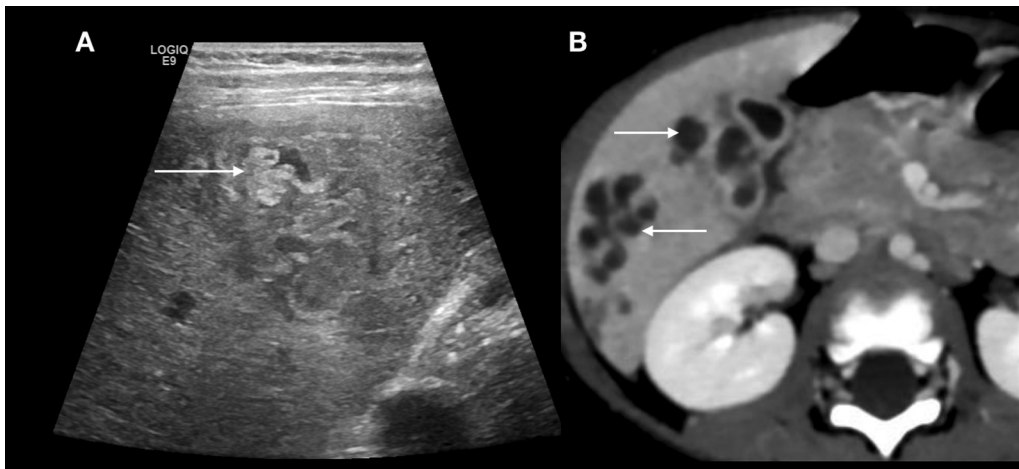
A young female with fever and eosinophilia. Outside computed tomography (CT) report of liver abscesses. Follow-up CT was done followed by ultrasonography (USG). Transverse USG (A) image showing irregular heteroechoic track with echogenic central and marginal areas. Axial CT (B) showing irregular branching tracks in the right lobe of liver extending up to the hepatic margins (tunnels and caves sign). Findings are suggestive of hepatic Fascioliasis. Partial resolution was seen on anti-helminthic treatment.
